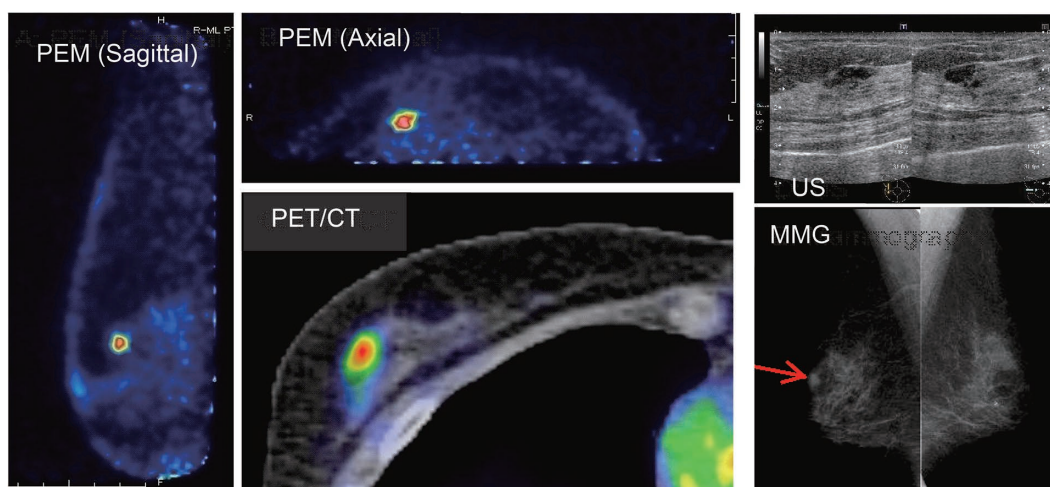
Comparison of the newly-developed PEM, PET/CT, US, and MMG in a typical case of an invasive ductal carcinoma ( $13 \times 9 \times 8 \text{ mm}$  in size).
